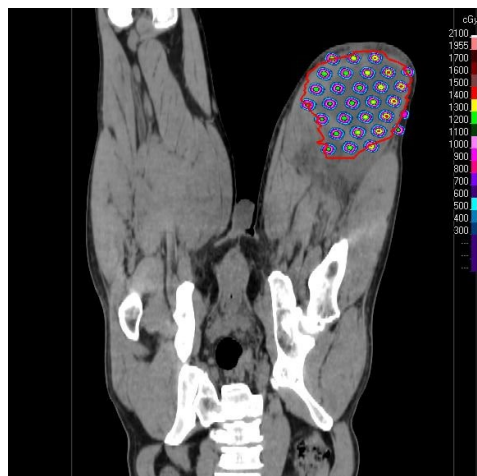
Coronal CT slice of SFGRT 15 Gy dose distribution for thigh sarcoma.
